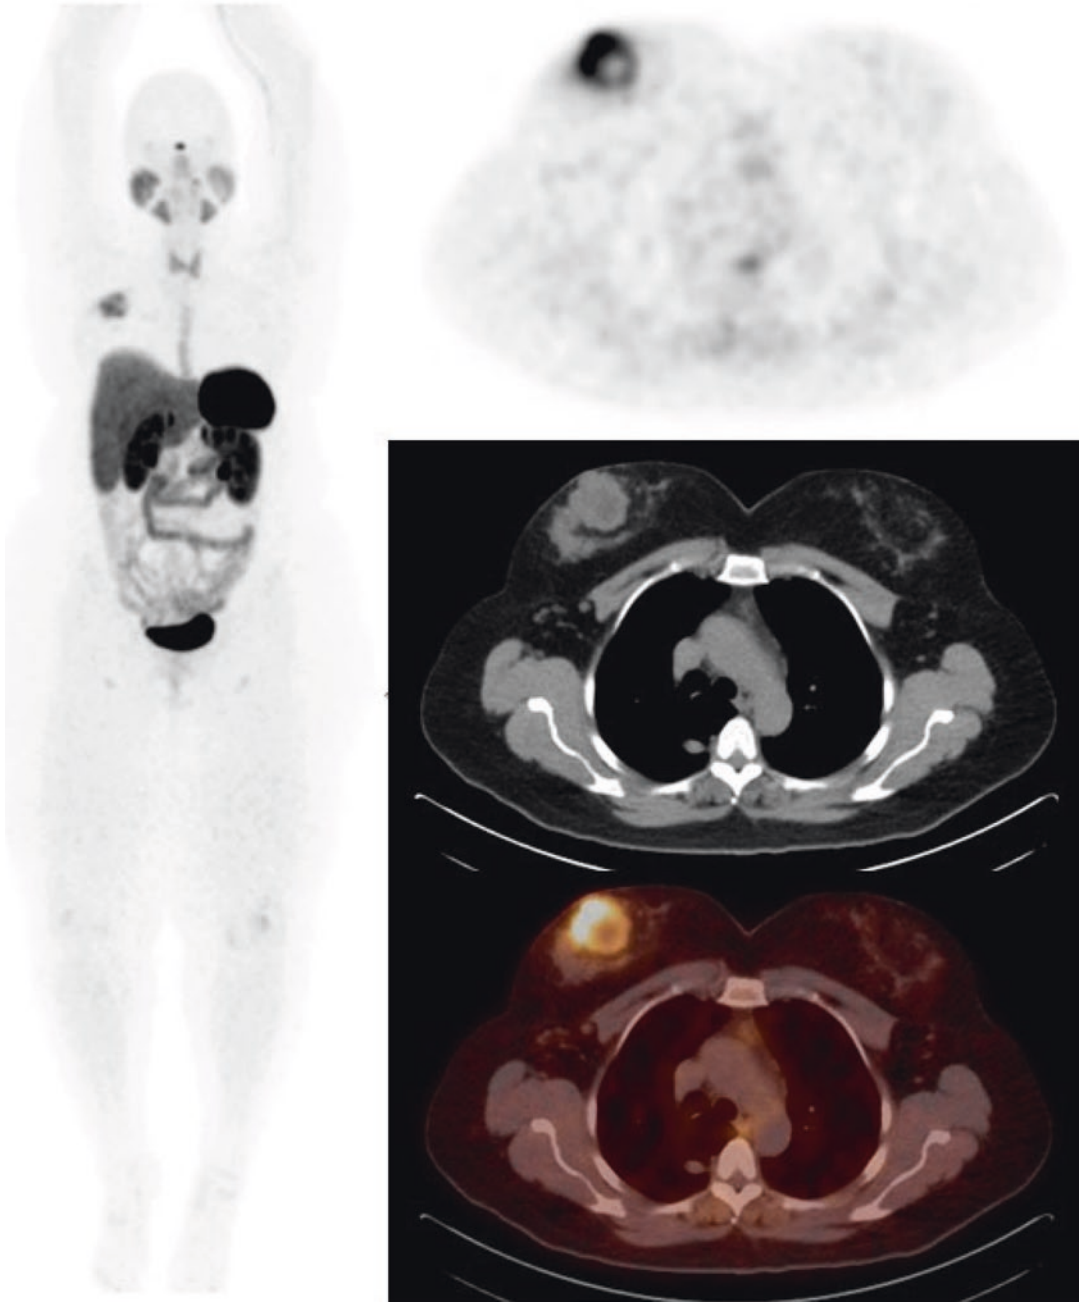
A 56-year old female with a neuroendocrine tumor of the breast. 68Ga Dotatate PET/CT demonstrating a mass in the right breast with central necrosis with no additional lesions
